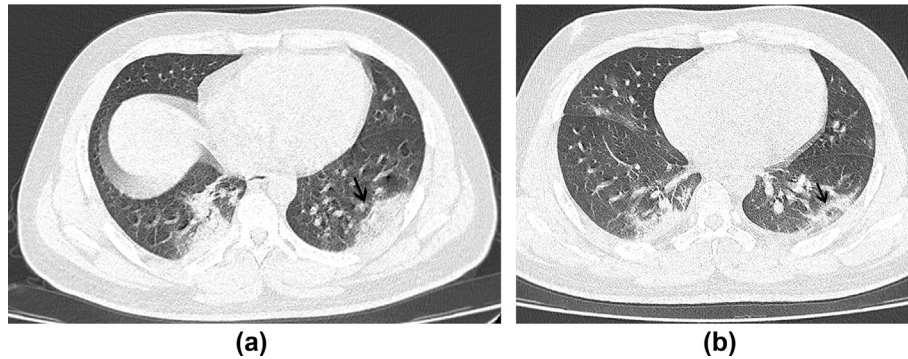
Male, 27 years old, with fever and fatigue for 5 days. a) chest CT obtained 5 days after the onset of symptoms. CT images shows consolidation of the right lobe and lower lobe of the lung. The lesions were close to the pleura. b). Follow-up CT obtained on 13 days after the onset of symptoms. The lesions were absorbed and the range was reduced. Lesions in the lower lobe of the left lung were absorbed from the center and showed a “reverse halo sign” (arrow).
